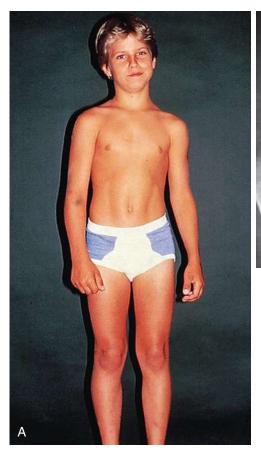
Legg-Calvé-Perthes disease. A, This 7-year-old boy is small for his chronologic age. He is bearing less weight on the involved right leg (note the slightly flexed right knee). On examination a hip flexion contracture, detected by a positive Thomas test (see Fig. 21-8, *B*), and an abductor lurch gait were found. B, In this anteroposterior radiograph, the right femoral epiphysis is flattened and fragmented. The proximal femur is also displaced inferiorly and laterally.
